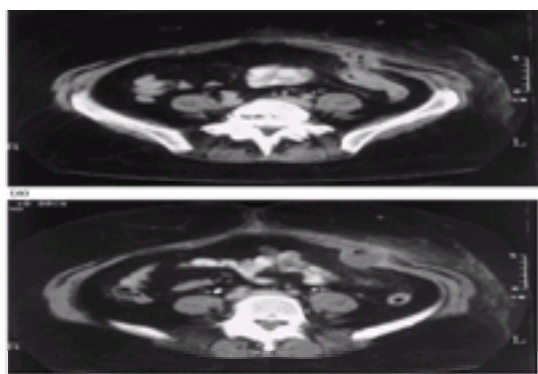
(a) and (b) CT scans showing subcutaneous abscess related to underlying diverticulitis.
